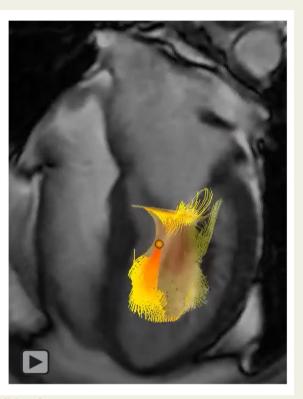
Figure I Multi-modality assessment of mixed mitral valve disease. Transthoracic echocardiography: Turbulent mitral regurgitation demonstrated in the apical two chamber with dilated left atrium (A). Velocity time integral-derived mean pressure gradient through the mitral valve (B) was 12 mmHg and the pressure half-time (C) estimated the mitral valve area to be 1.82 cm². On transoesophageal echocardiography, severe mitral regurgitation is seen in two-chamber (D) and on three-dimensional reconstruction of the mitral valve (E) the degree of mitral stenosis does not appear to be severe. On velocity time integral (F), the mean pressure gradient was 6 mmHg. On four-dimensional flow cardiovascular magnetic resonance, the peak mitral inflow velocity was traced throughout the diastole using plane with maximum velocity (G) and during systole (H), a reformatted plane was generated perpendicular to the mitral regurgitation jet in the left atrium (H). On short-axis cine, mitral valve area was 2.1 cm² at the tips of mitral valve (I). The mean pressure gradient for mitral inflow was 6 mmHg (I). T1-mapping (I) and extracellular mapping demonstrated normal myocardium. There was no evidence of left ventricular scar on late gadolinium enhancement (I). Invasive haemodynamic assessment was done using a multipurpose catheter placed for the capillary wedge pressure and a pigtail catheter within the left ventricle to allow recording of simultaneous pressures (I). The simultaneous pressure tracings of left ventricle and pulmonary capillary wedge are demonstrated (I).
